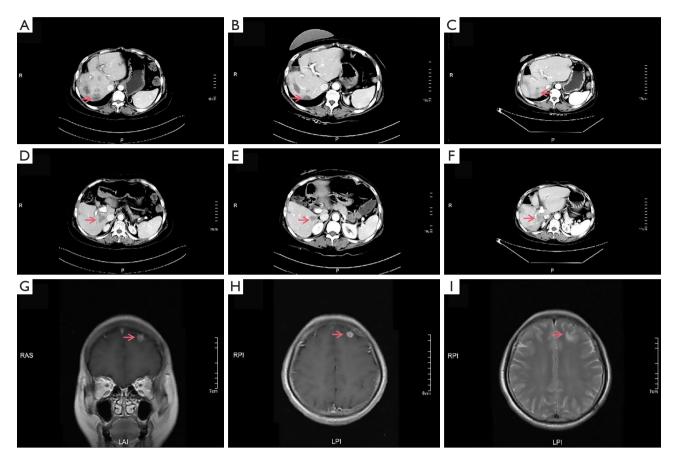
Case 1. On May 16, 2017, before "anastrozole, herceptin, apatinib" treatment. (A) Liver lesion  $(4.1\times3.0 \text{ cm}^2)$ ; (D) liver lesion  $(3.0\times2.0 \text{ cm}^2)$ ; (G) retroperitoneal lymph node lesion  $(2.7\times1.8 \text{ cm}^2)$ . On July 18, 2017, after "anastrozole, herceptin, apatinib" treatment, CT showed partial response. (B) Liver lesion reduced to  $2.6\times1.7 \text{ cm}^2$ ; (E) liver lesion reduced to  $2.0\times1.8 \text{ cm}^2$ ; (H) retroperitoneal lymph node lesion increased to  $2.0\times1.1 \text{ cm}^2$ . On January 24, 2018, disease progressed. (C) Liver lesion increased to  $2.9\times2.3 \text{ cm}^2$ ; (F) liver lesion increased to  $3.0\times2.3 \text{ cm}^2$ ; (I) retroperitoneal lymph node lesion reduced to  $2.1\times1.7 \text{ cm}^2$ . The arrows indicate lesions in the liver and retroperitoneal lymph nodes. CT, computed tomography.
